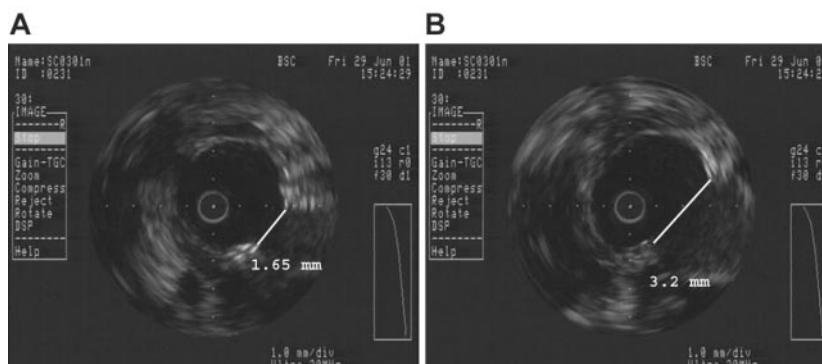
Intravascular ultrasound images of clipped anastomosis at (A) minimum opening width and (B) maximum opening width.
